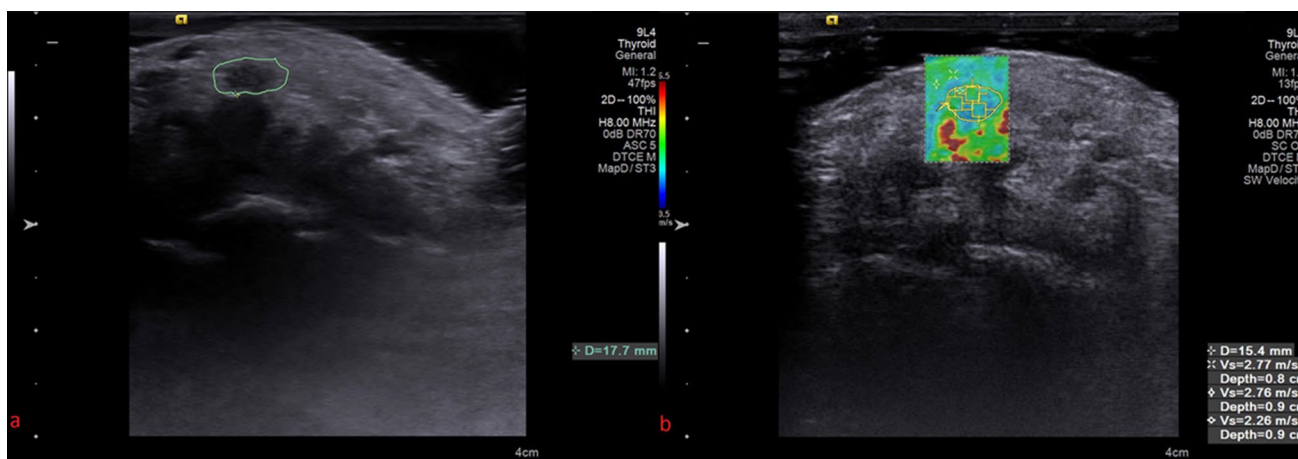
For the session without compression, a thick ultrasound gel layer is visible in both the B-mode (a) and the ARFI (b) ultrasound images. The display scale of the color map is 0.5–10 m/s. The color correlates with tissue stiffness. In general, red, green, and blue areas
